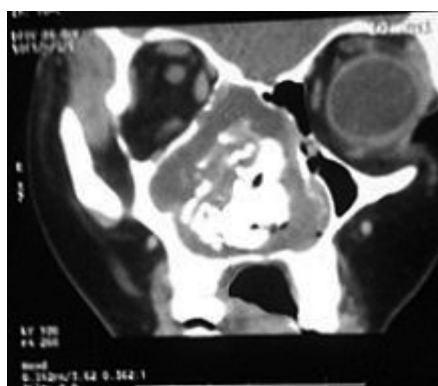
CT scan showing opacification of right and left nasal cavity
